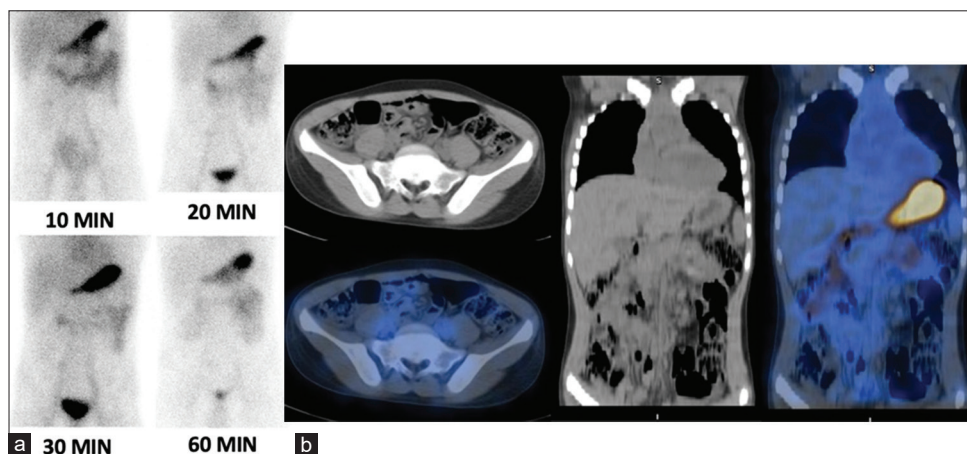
(a and b) After administering 270 MBq (7.3mCi) Tc-99m sodium pertechnetate intravenously, sequential images of the anterior abdomen were acquired for 60 min. The left upper quadrant activity accumulation was that of gastric mucosa in the stomach (thick arrow). However, no other focus on abnormal radiotracer accumulation was noted during the study. A corroborative SPECT/CT also confirmed the findings. Hence, the study showed no evidence of an ectopic functioning gastric mucosa. The patient was discharged on proton-pump inhibitors. After almost 1.5 months of this event, the patient again had a similar bleeding episode. Since a definitive diagnosis could not be reached previously, the patient was reinvestigated thoroughly again this time. A repeat of Meckel's scan was also performed. SPECT/CT: Single-photon emission computed tomography/computed tomography
